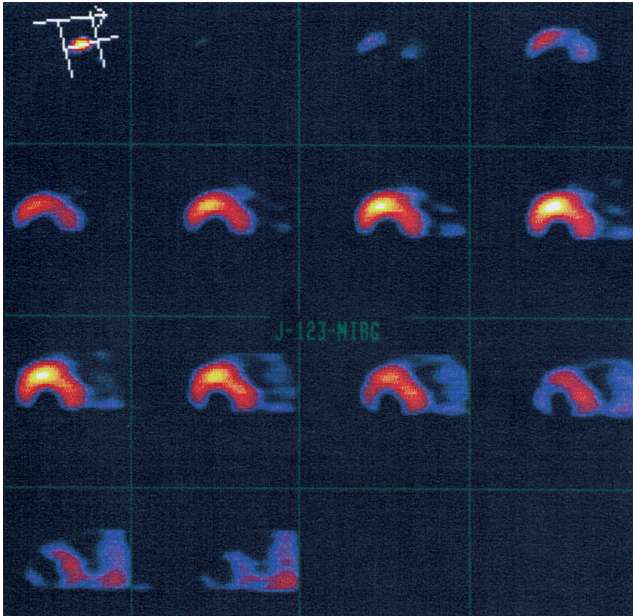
Abnormal MIBG-SPECT with lack of activity in the dorso-septal heart muscle.
